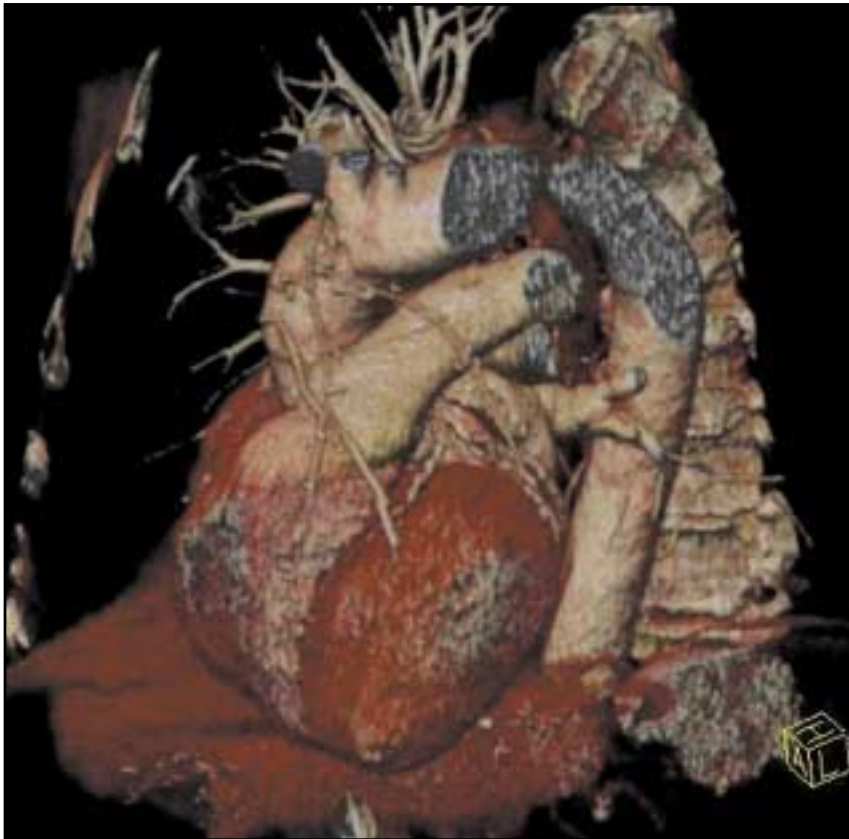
Assessment of bypass graft patency is a common application of CTA.
